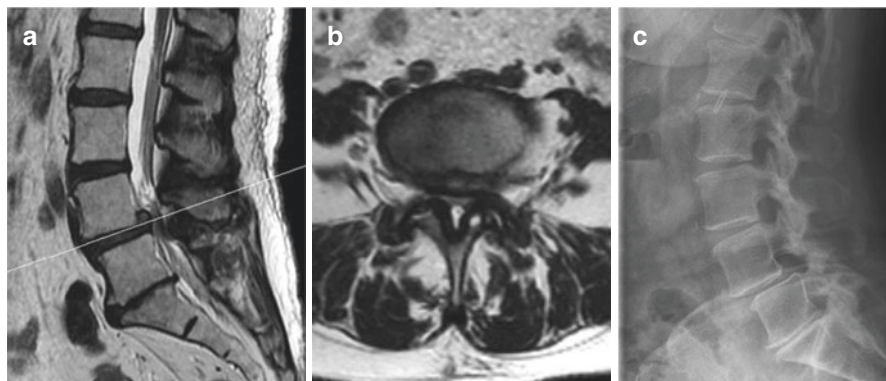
Spondylolisthesis at Lumbar 4–5 with spinal stenosis. (a) MRI Lumbar spine T2 sagittal shows grade 1 spondylolisthesis with disk herniation causing spinal stenosis at the L4–5 level. (b) MRI Lumbar spine T2 axial shows a broad-based disk with resultant severe lumbar spinal stenosis. (c) Standing plain film X-Ray shows dynamic instability with increase in spondylolisthesis at that level
